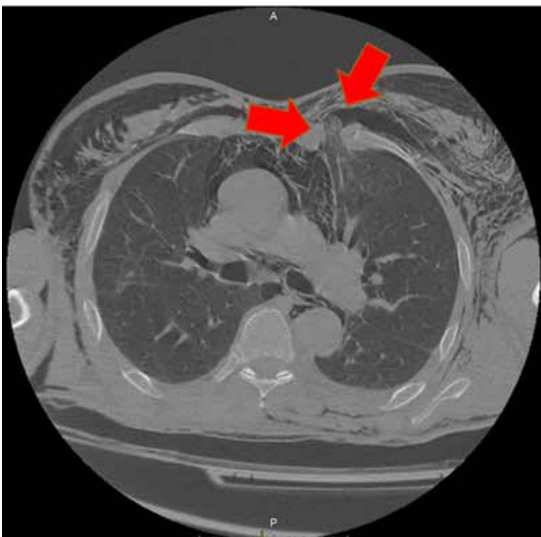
Axial view of chest computed tomography image that shows the left lung that herniates through a chest wall defect (red arrows).
